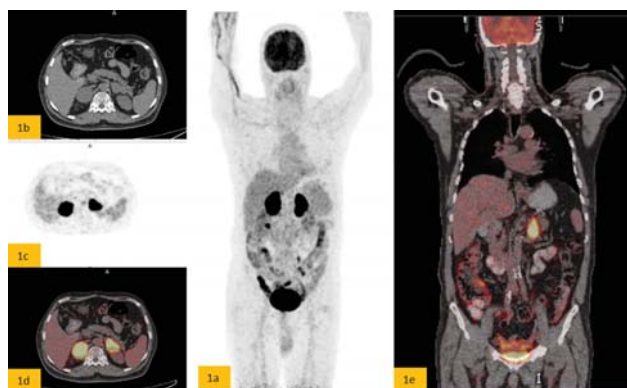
(a-e): ¹⁸FDG PET/CT imaging. (a) Maximum intensity projection (MIP) image showing bilateral hypermetabolic adrenal lesions. Axial CT (b), PET (c) and fused (d) and fused coronal image (e) show isolated bilateral hypermetabolic adrenal masses but no other ¹⁸FDG avid disease.
